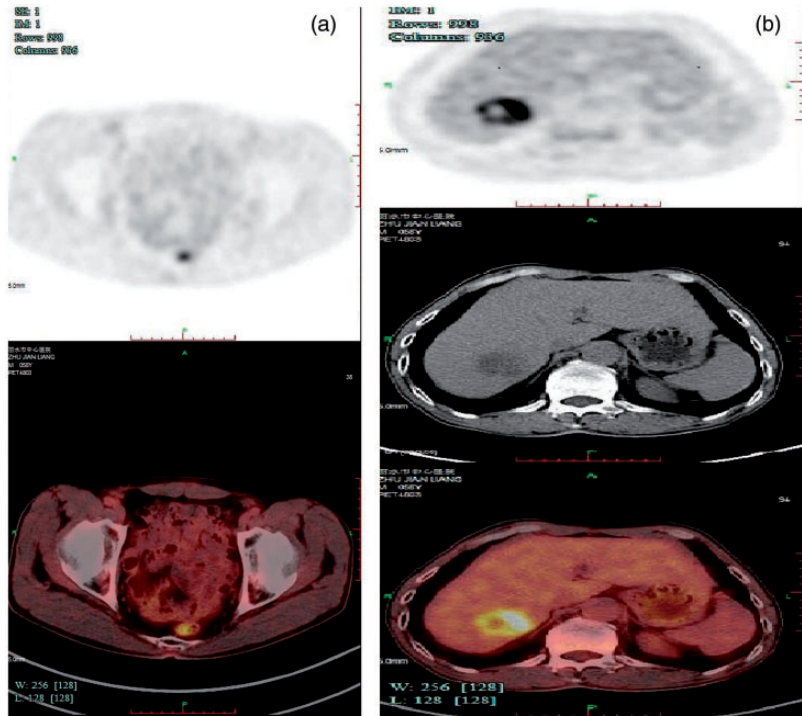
¹⁸F-FDG positron emission tomography. The upper rectum showed local thickening of the intestinal wall and elevated radioactive intake (maximum standardised uptake value, 5.4). Low density was observed in the right posterior lobe of the liver with elevated radioactive intake (maximum standardised uptake value, 9.1).
